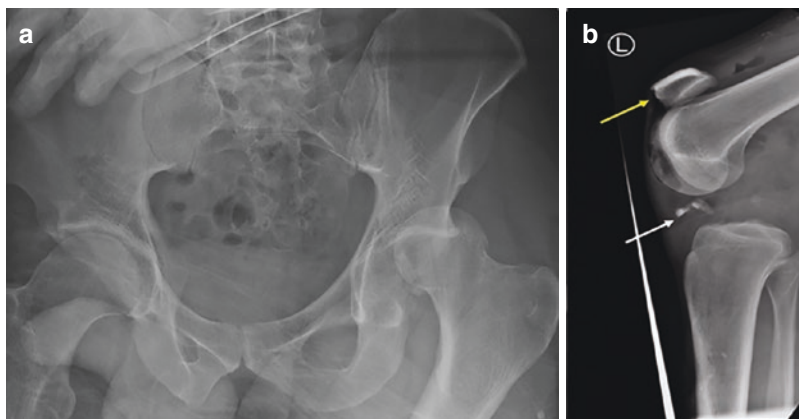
A lateral radiograph of the left knee demonstrating a displaced transverse patellar fracture (white arrow)
